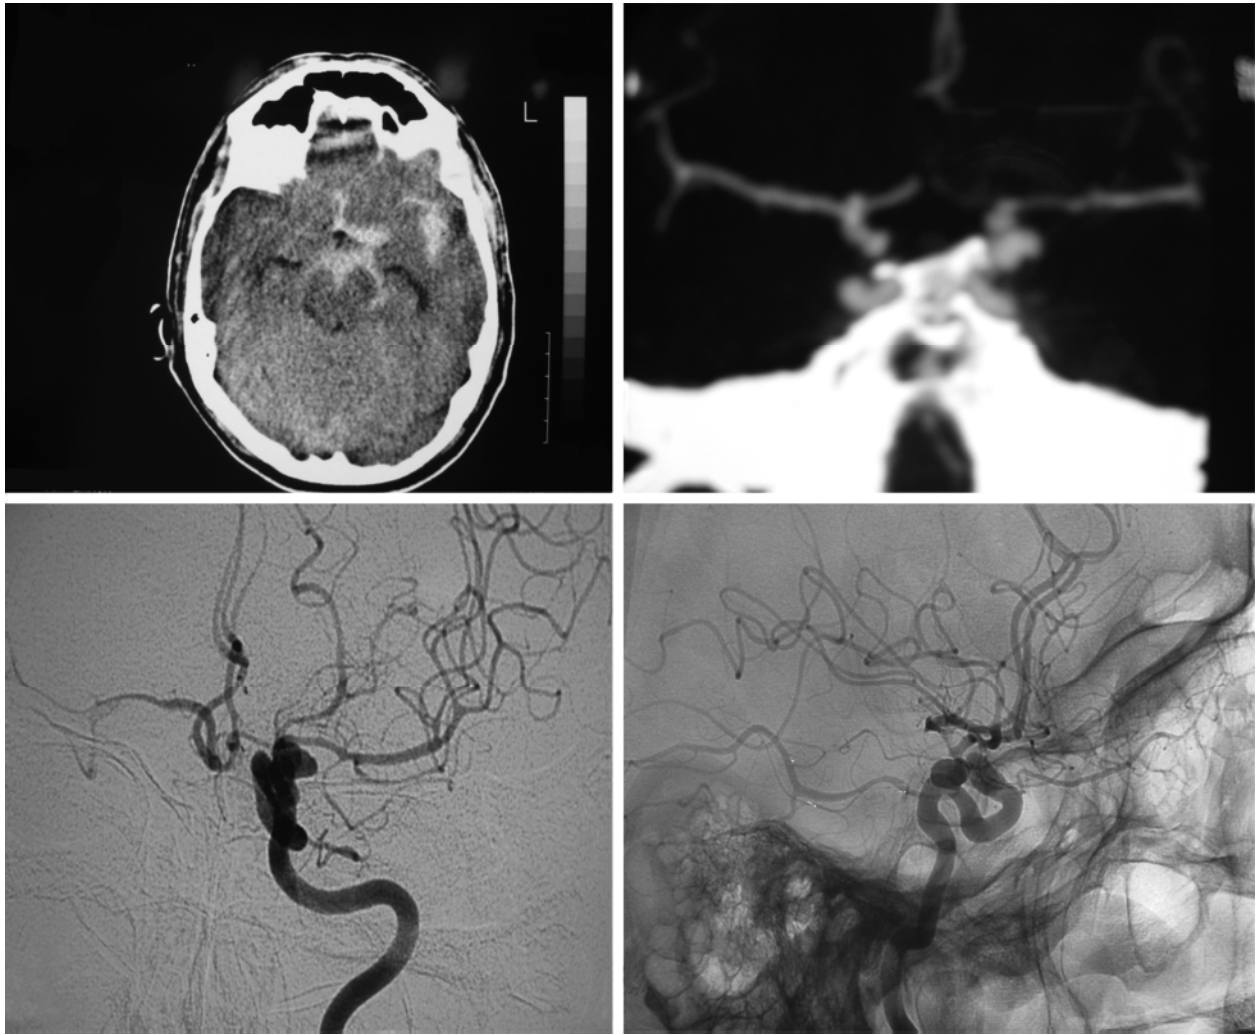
Computed tomography angiography and digital subtraction angiography—Sylvian peri-mesencephalic bleed due to ventrolateral internal carotid artery aneurysm left
